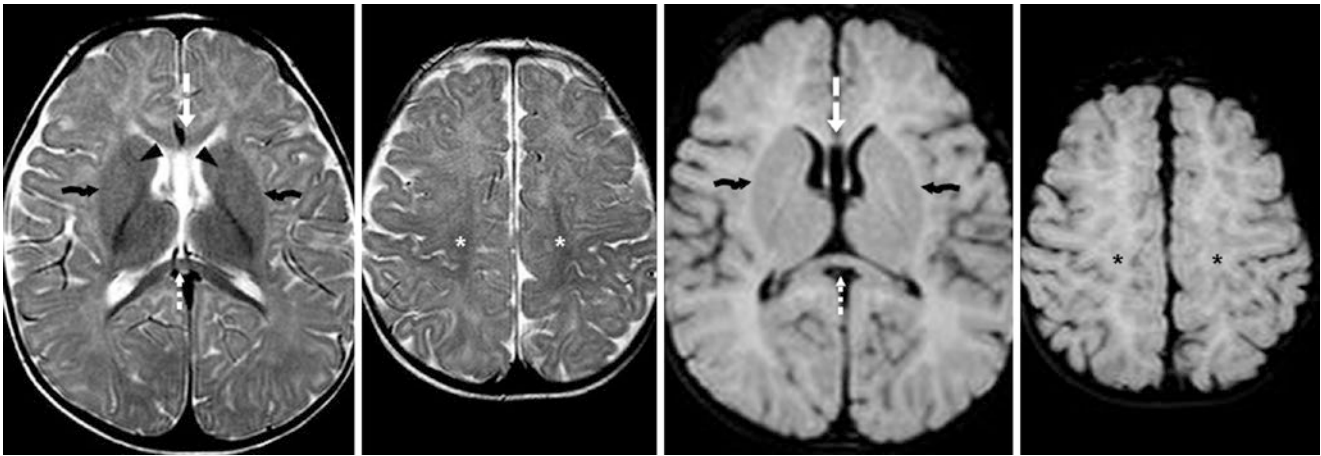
A 7.5-month-old with developmental delay with a negative 3T MRI. SE T2WIs (left images) and FLAIR (right images) show early maturation of the ALIC (arrowheads), CG (dashed arrows), and ECs (crooked arrows), which are all mildly dark, but not as much as the CS
